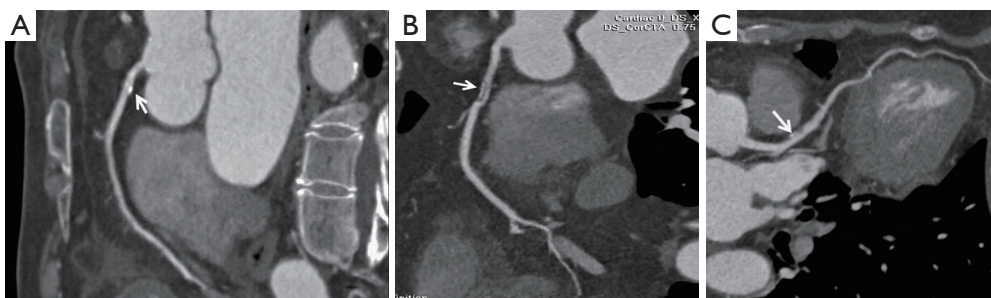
Coronary CT angiography characterization of plaque composition. (A) A calcified plaque (arrow) is seen in the proximal segment of right coronary artery in a 65-year-old woman with suspected coronary artery disease; (B) a non-calcified plaque (arrow) is detected in the proximal segment of right coronary artery in a 67-year-old woman with known coronary artery disease; (C) a mixed plaque (arrow) is observed in the proximal segment of left anterior descending coronary artery in a 55-year-old female with suspected coronary artery disease. CT, computed tomography.
